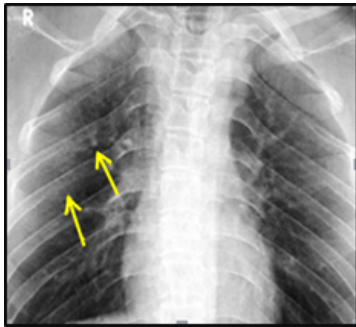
Radiograph of the thorax (AP) view showed ribbon ribs & inferior rib notching due to intercostal neurofibromas. (Yellow arrows)
